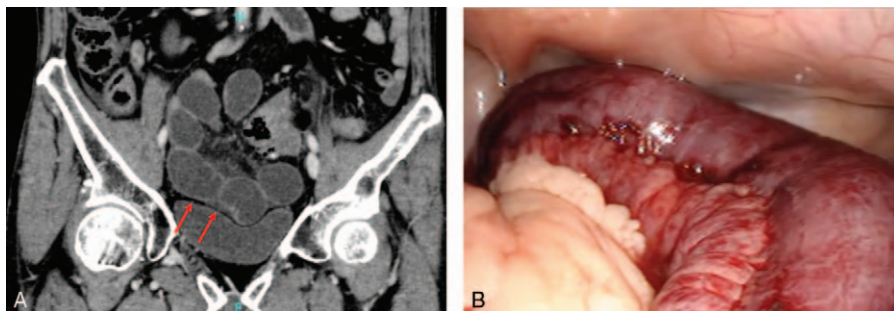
(A) Contrast CT images in Case 1. A closed loop obstruction was detected around sigmoid colon (red arrow). (B) Representative photograph of Case 1 during surgery. A loop ileum had herniated through an orifice formed by adhesion of the greater omentum to the perforated part of the sigmoid colon.
